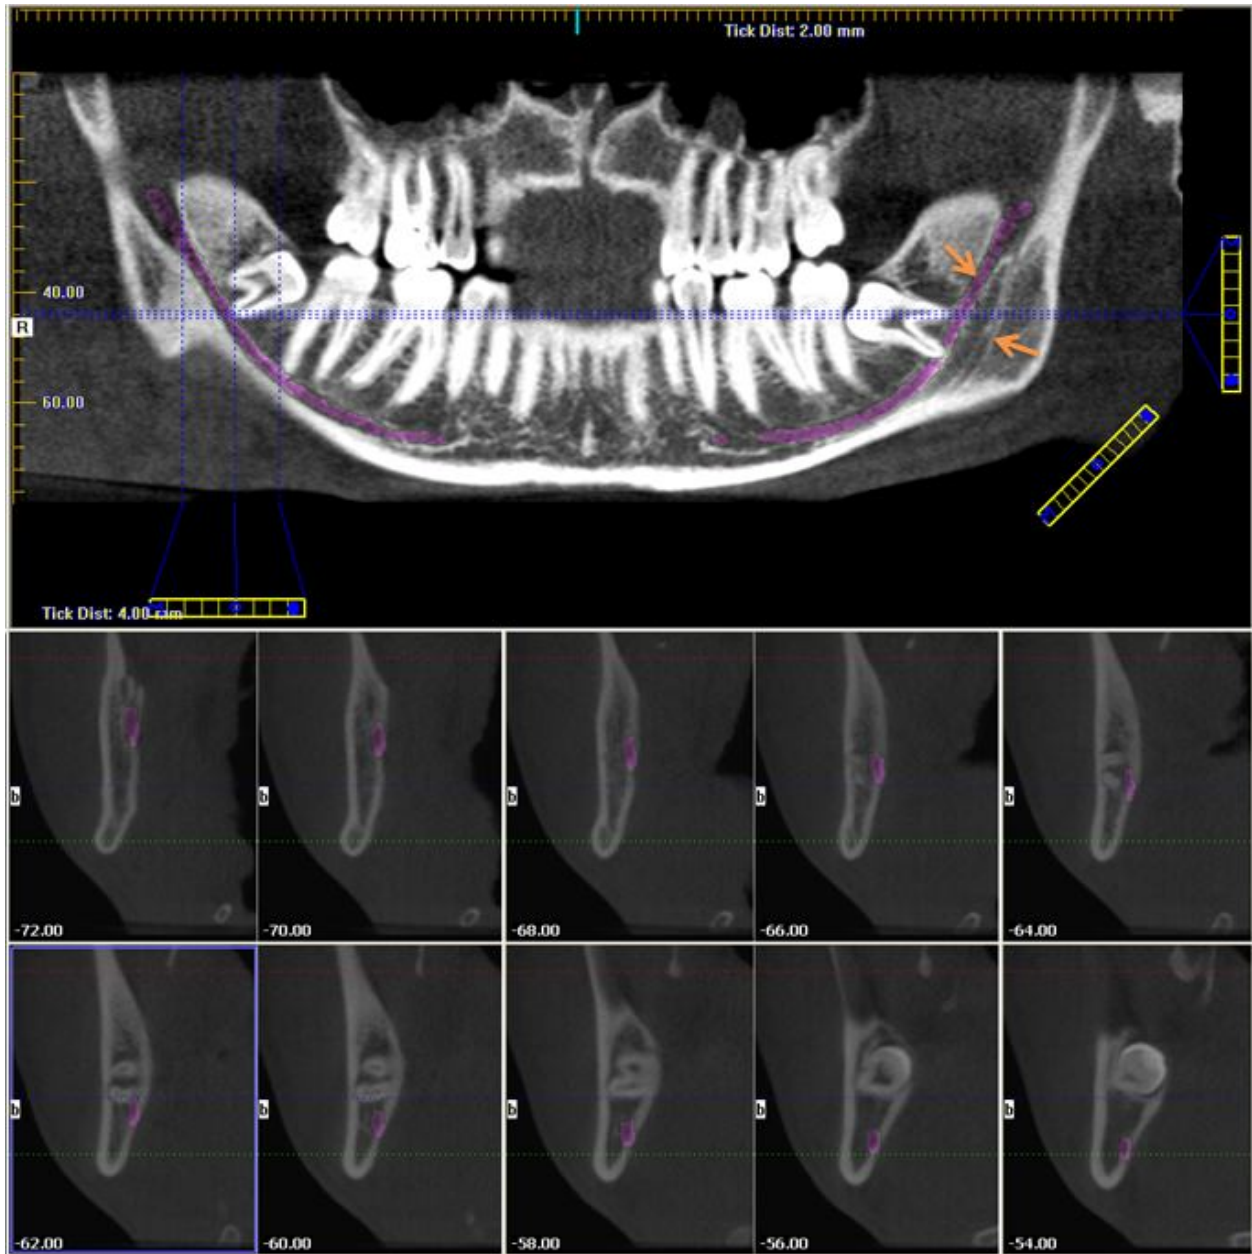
Digital panoramic radiograph showing the path of the MC (arrows)*
